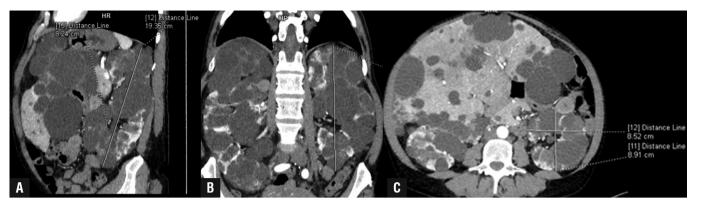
Abdominal CT scans in arterial phase: A. kidney length in the sagittal plane; B. kidney length in the frontal plane; C. kidney width and thickness in the transverse plane
